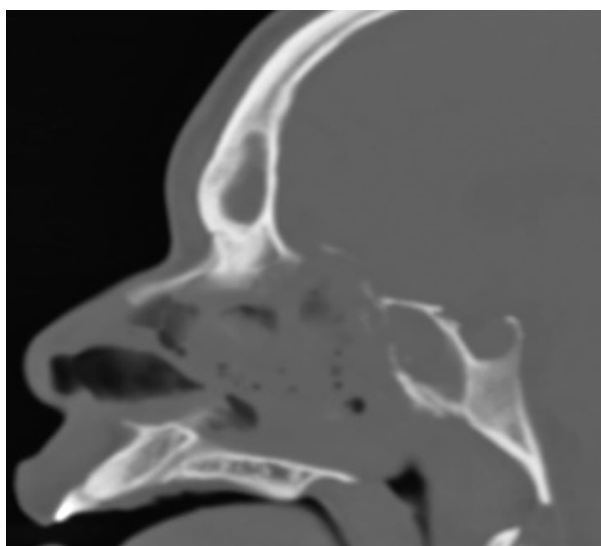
Postoperative non-contrast CT sinus sagittal view after removal of foreign body demonstrating persistent elevation of anterior skull base. CT indicates computed tomography.
